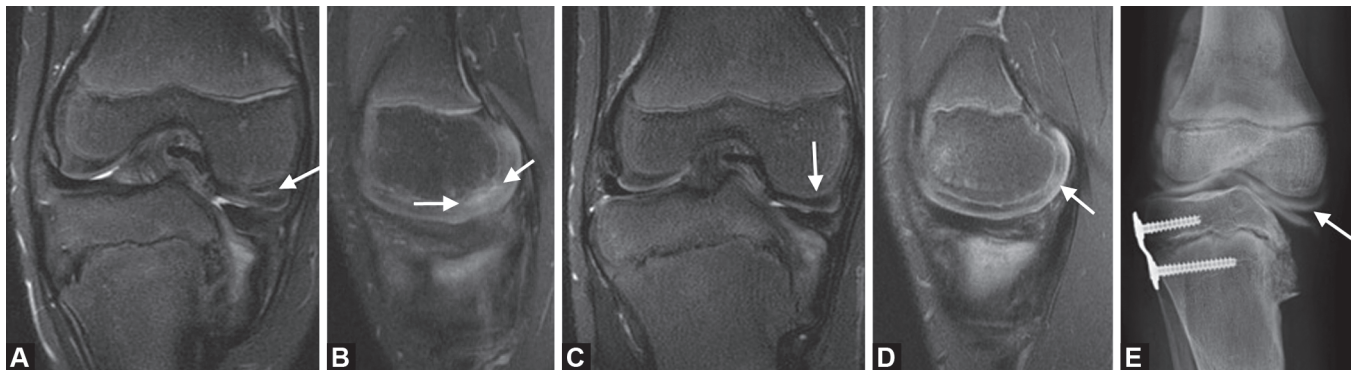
A 3-year-old boy with early-onset Blount disease. Coronal (A) and sagittal (B) fat-suppressed T2-weighted images demonstrate a fluid-filled cleft (white arrows) in the hypertrophied medial femoral condylar cartilage. The surface of the articular cartilage is intact. There is slight medial meniscal hypertrophy
